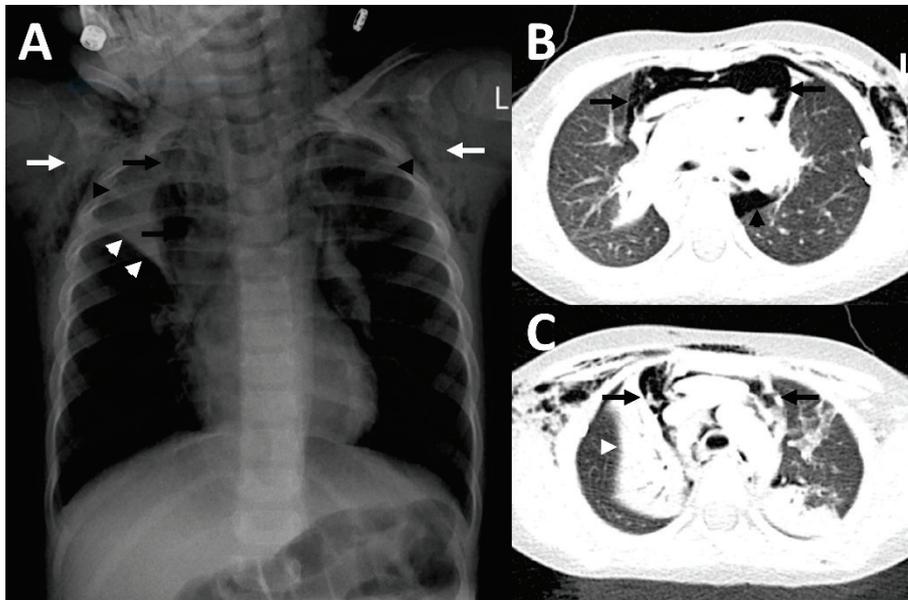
Imaging findings in patient 2. In the chest x-ray (A), as well as in CT-imaging (B,C) bilateral subcutaneous emphysema (white arrows) and a pneumomediastinum (black arrows) with a Spinnaker sail (angel wing) sign ((A), thymus lobes marked with black arrowheads) was detected. In addition, there were atelectases (white arrowheads), predominantly of the right upper lobe, as well as a pneumothorax (black arrowhead in (B)).
